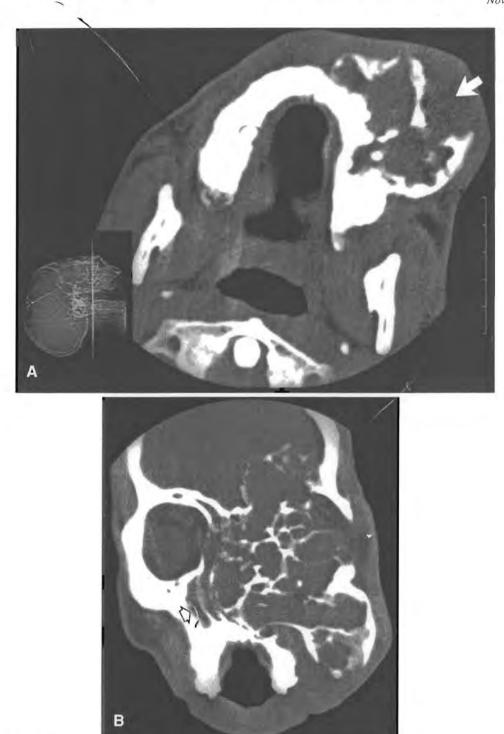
A, Axial CT scan at level of maxilla showing buccal expansion and cortical perforation (arrow). B. Coronal CT scan through orbits showing tumor expanding intracranially, obliterating left maxillary antrum. left orbit, nasal cavities, ethmoidal sinus, left frontal sinus, and displacing medial wall of right antrum (arrow) and of right orbit. Note lack of palatal expansion.
